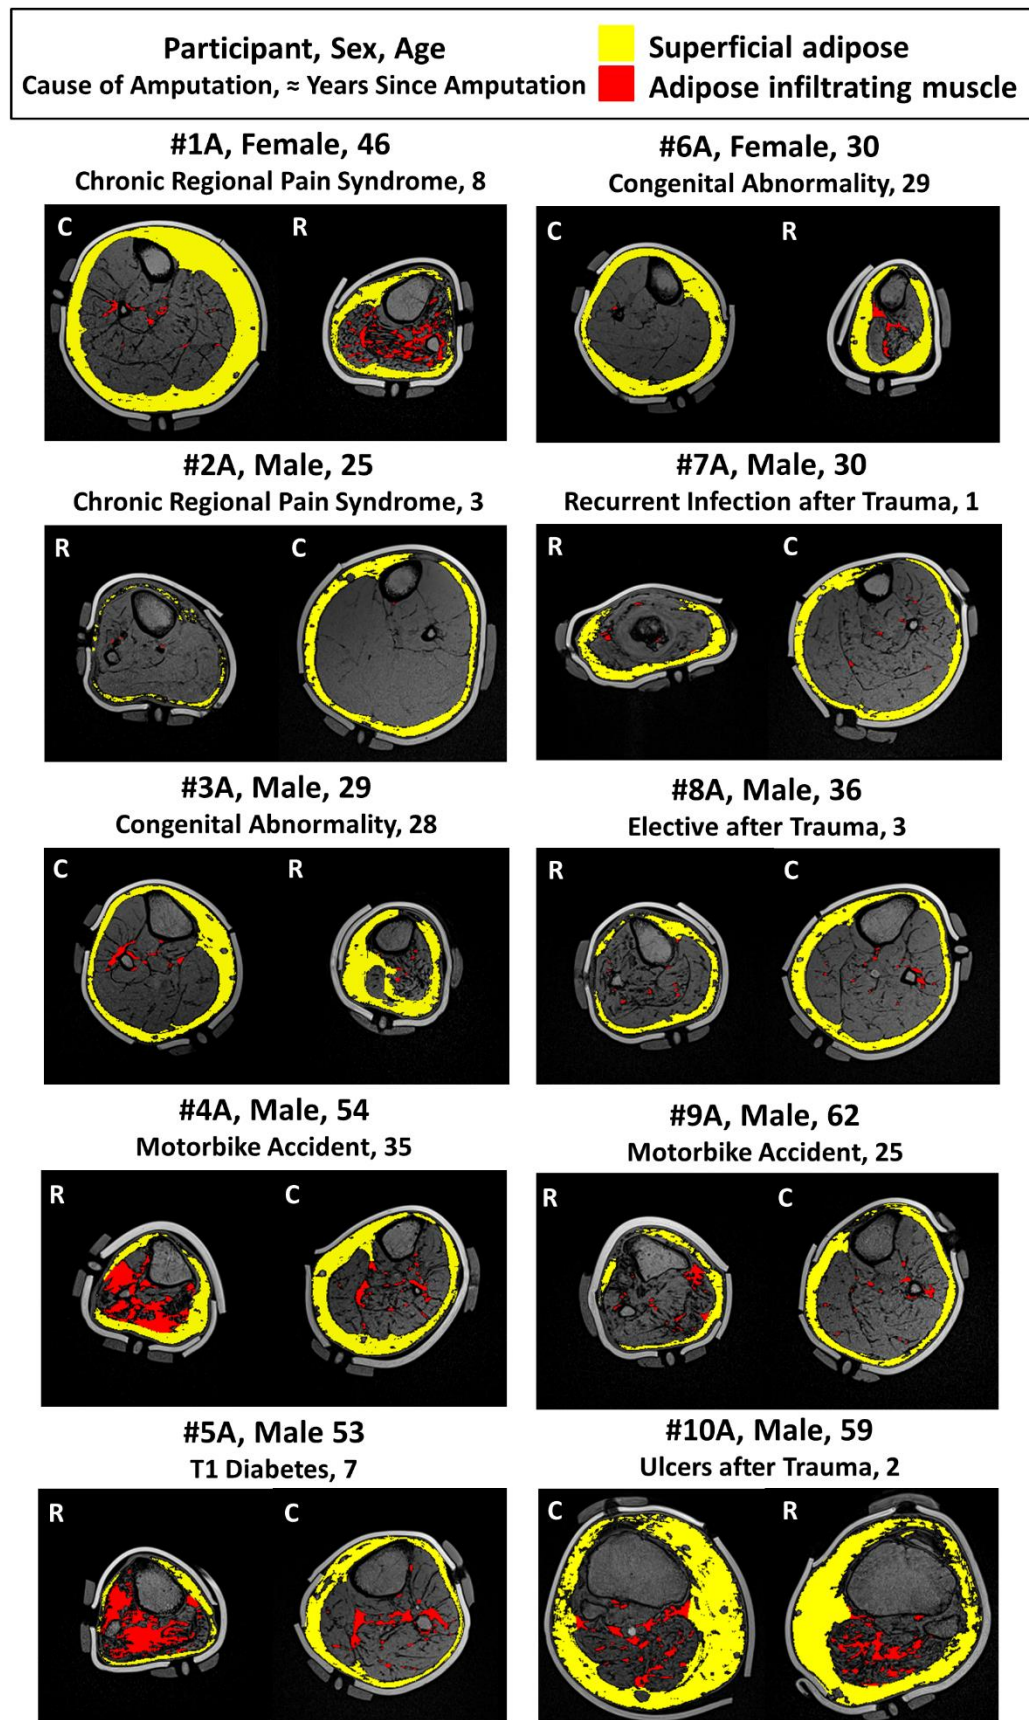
Corresponding transverse MRI slices at the posterior calf measurement site for the residual (R) and contralateral (C) limbs of ten participants with unilateral transtibial amputation, with superficial adipose (yellow) and adipose infiltrating muscle (red) tissue overlays
